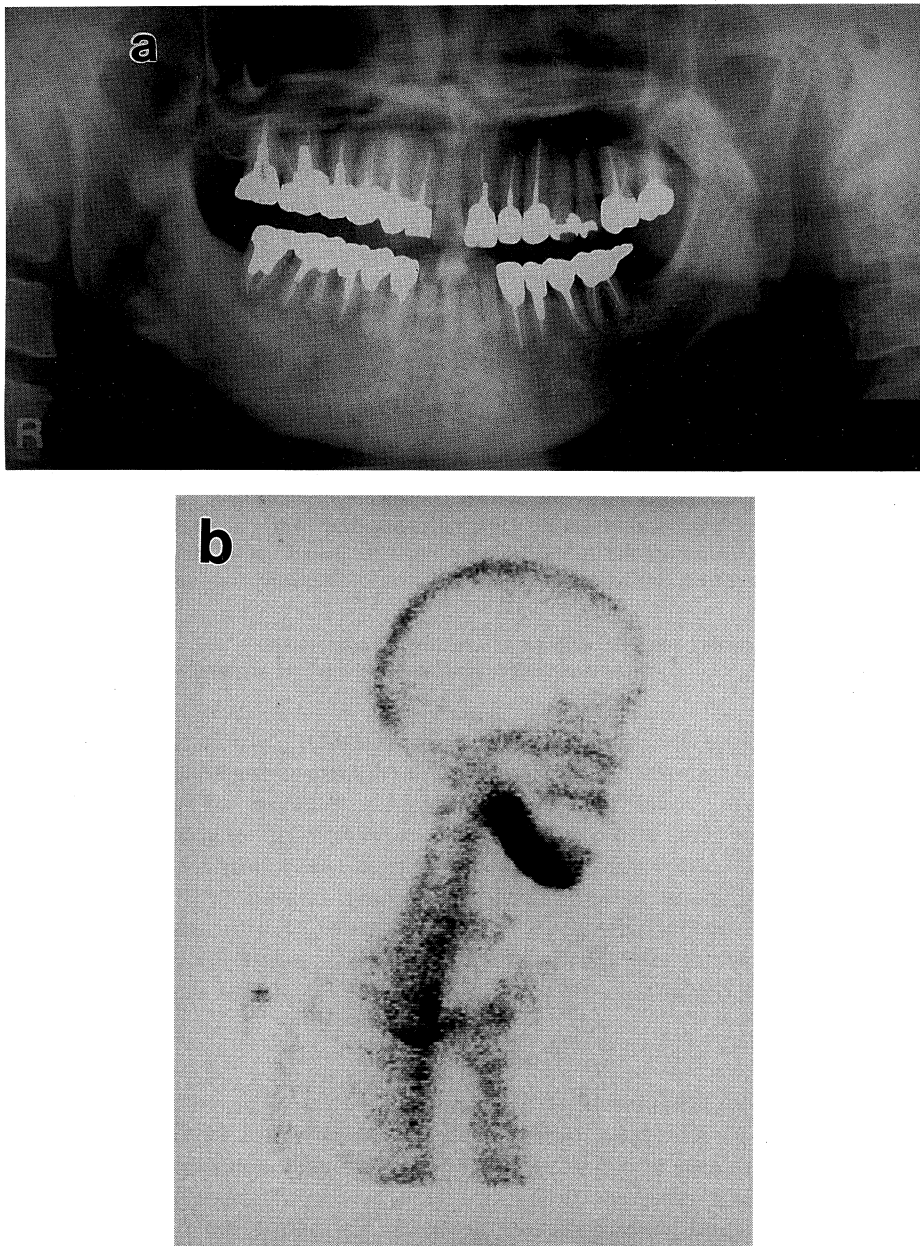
Radiographic examinations at the first visit
